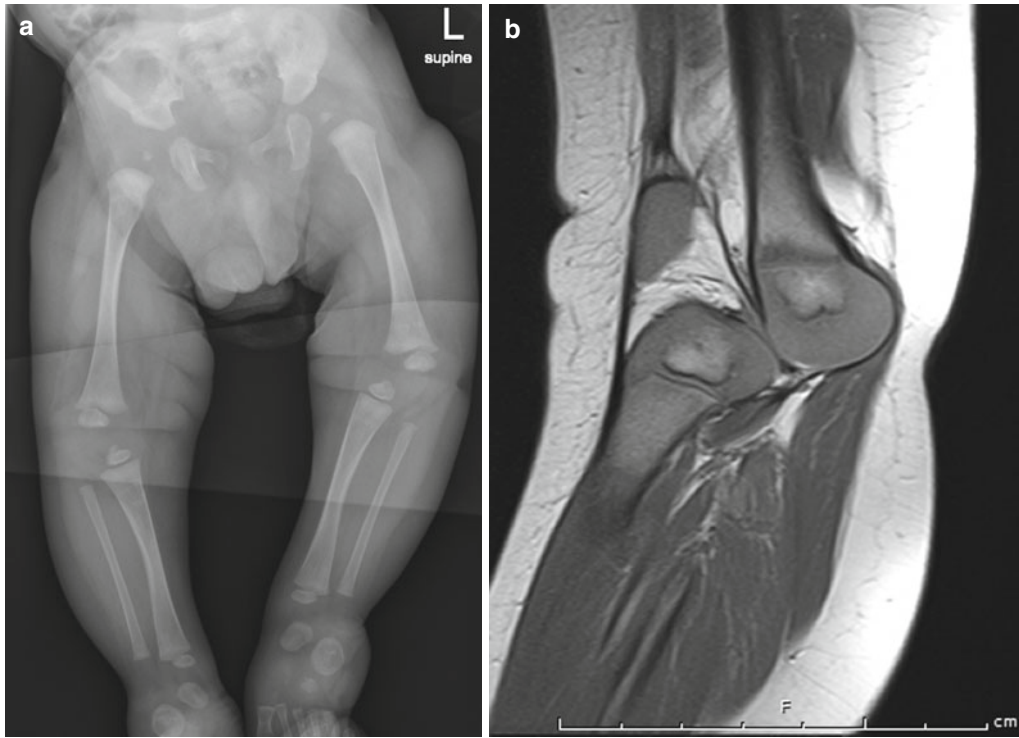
(a) An AP radiograph of the lower extremities of a child with Larsen syndrome and bilateral congenital knee dislocations. Note the anterior displacement of the tibia relative
